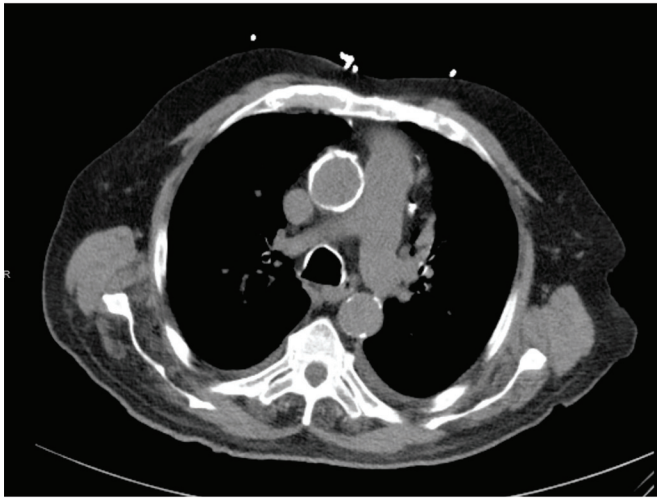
Preoperative CT scan of the chest shows severe calcification of the ascending aorta (left), and mild disease on the descending aorta.
